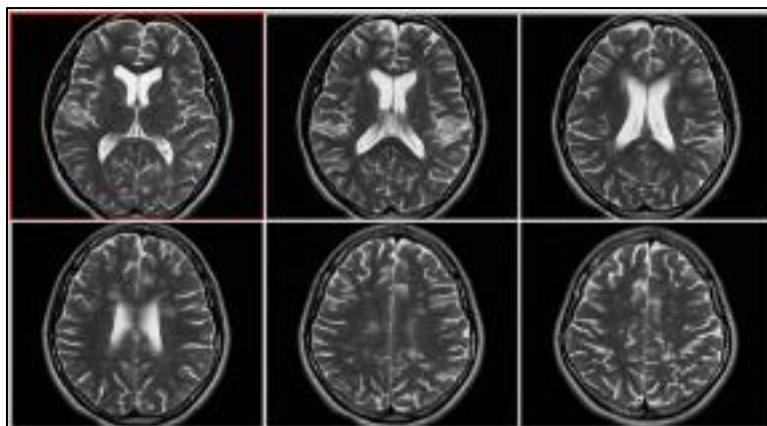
Multiple white matter hyperintensities on T2 MRI consistent with demyelinating lesions of multiple sclerosis
